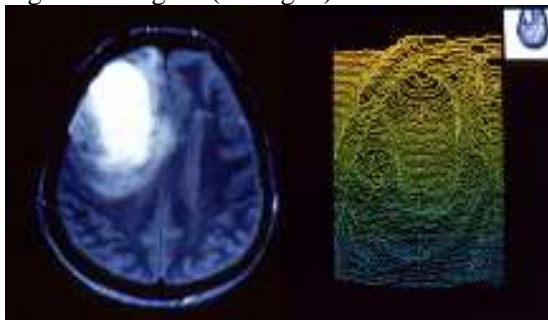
MRI image of tumour (left) and contrasted grey level at the border of the tumour (right)
